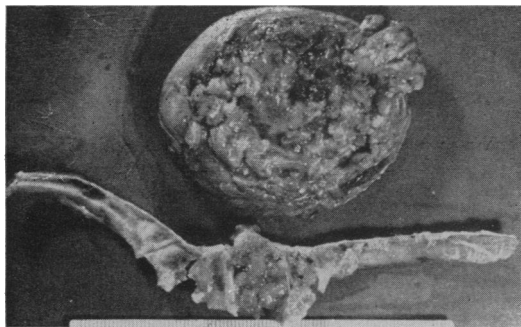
Tumor and rib removed from patient whose roentgen ray is shown in Figure 3.
